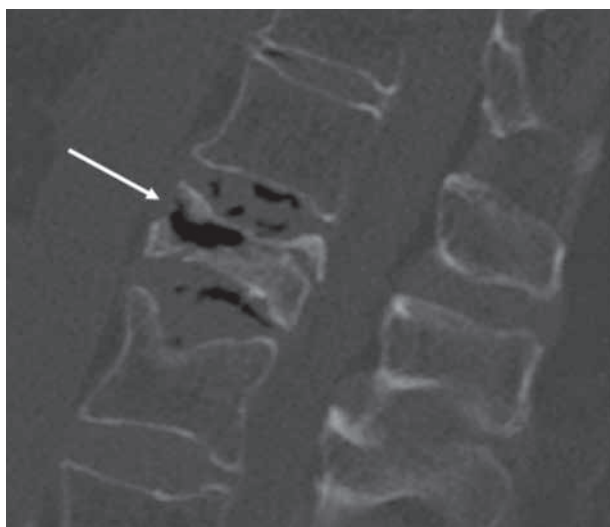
Sagittal CT image of L1 showing the pathognomonic intravertebral cleft (white arrow) in an 81 yo female patient with persisting back pain 10 weeks after onset of initial symptoms.
